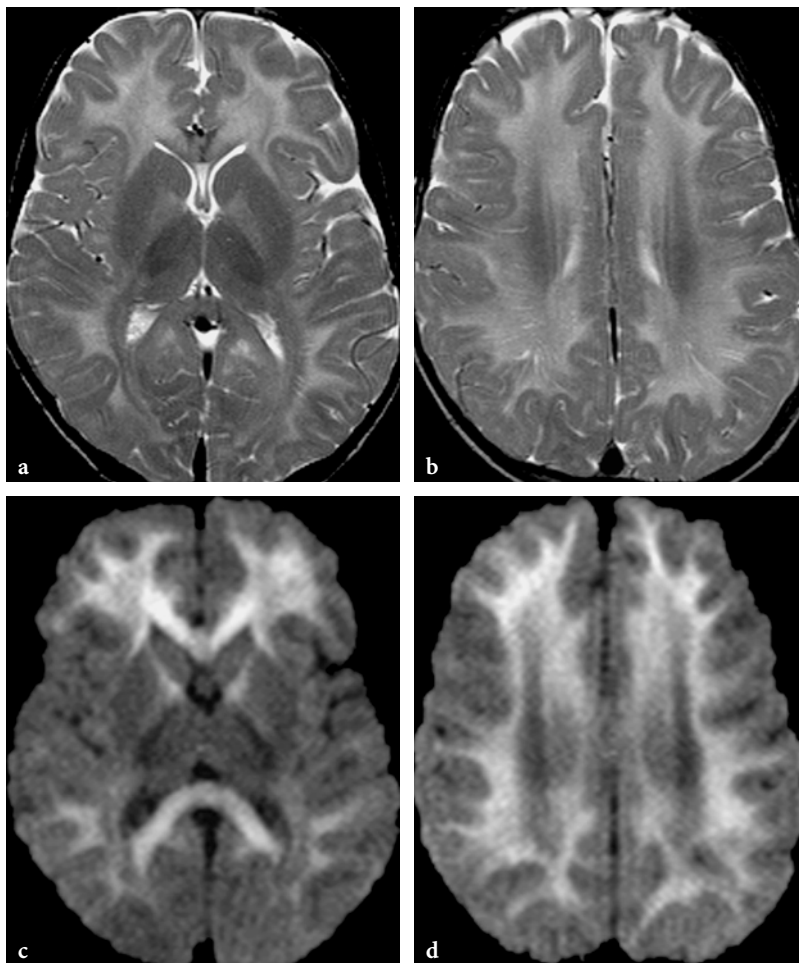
Conventional and diffusion-weighted MR imaging findings in a 5-year-old male patient with 5,10-methylene-tetrahydrofolate reductase deficiency. a,b Axial T2-weighted fast spin-echo images. White matter abnormalities show a fairly similar pattern to that seen in cystathionine β -synthetase deficiency (see Fig. 13.59). Perhaps the globus pallidus lesions are more prominent. c,d Axial diffusion-weighted echo-planar images. White matter lesion areas are hyperintense, suggestive of active demyelination with myelin edema
